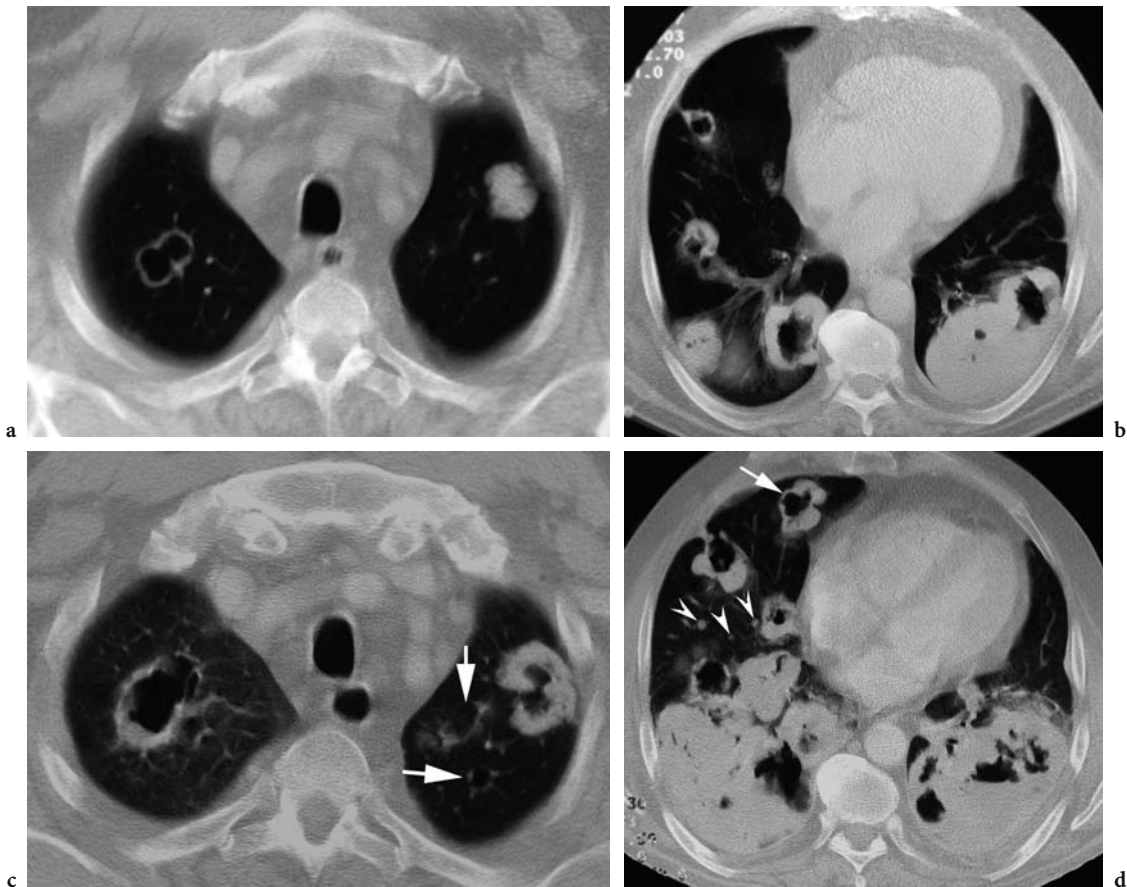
Mixed nodular and cystic lung metastases in a 67-year-old woman who underwent nephrectomy for renal cell carcinoma. a Axial CT scan of the upper chest shows a left solid oval pulmonary nodule and a right cystic lung nodule showing a thin and smooth wall. b Axial CT scan of the lower chest shows several bilateral excavated lung nodules. The left posterior mass is probably secondary to several confluent nodules. c, d Five-month follow-up axial CT scans at the same levels as a and b show enlargement of both solid and cystic nodular lesions. There are also new solid micronodules (*arrowheads*) and cystic nodules (*arrows*).
